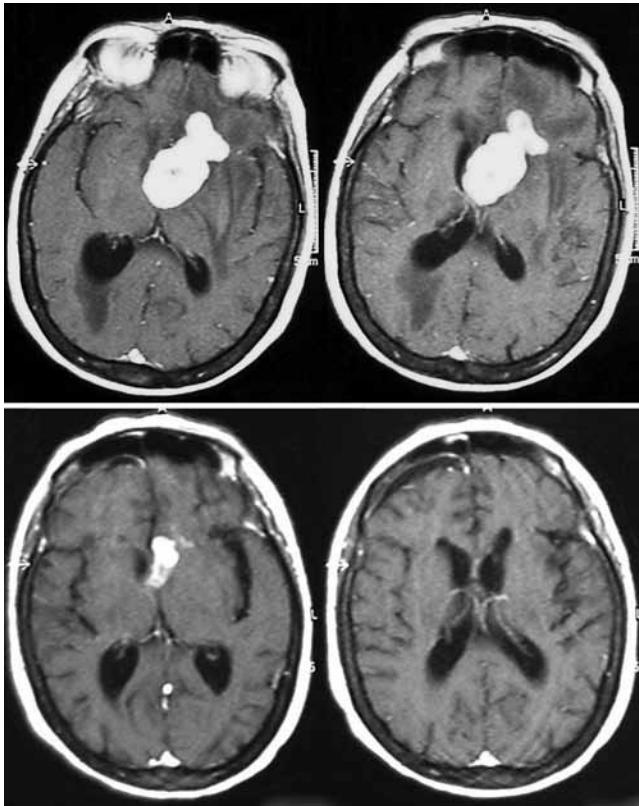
Axial MR images obtained in a 65-year-old woman with a large intraventricular lymphoma. Upper: Preoperative images showing the lesion. Lower: Six months after the biopsy and septostomy, the images show remarkable tumor reduction during chemotherapy.
